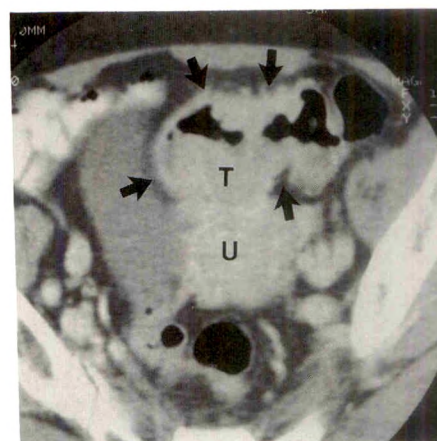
Adenocarcinoma of sigmoid colon. Magnified CT scan shows narrowed irregular sigmoid lumen and circumferential infiltration by a lobulated and asymmetric soft-tissue mass (arrows). Colonic tumor (T) is compressing uterus (U), and expected intermediary fat plane is obliterated.
